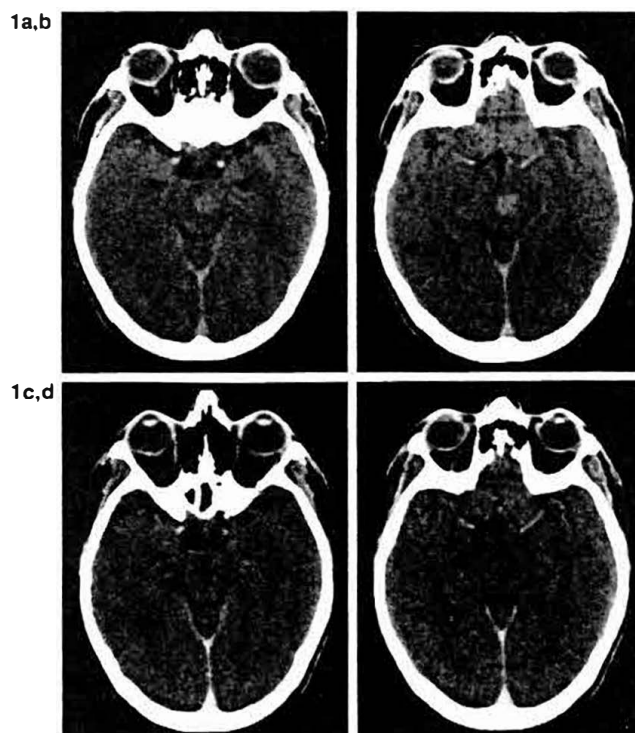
a and b: Contiguous postcontrast CT scans show slightly enhancing focal lesion in upper brain stem. c and d: Follow-up study 3 weeks later reveals normal findings.
